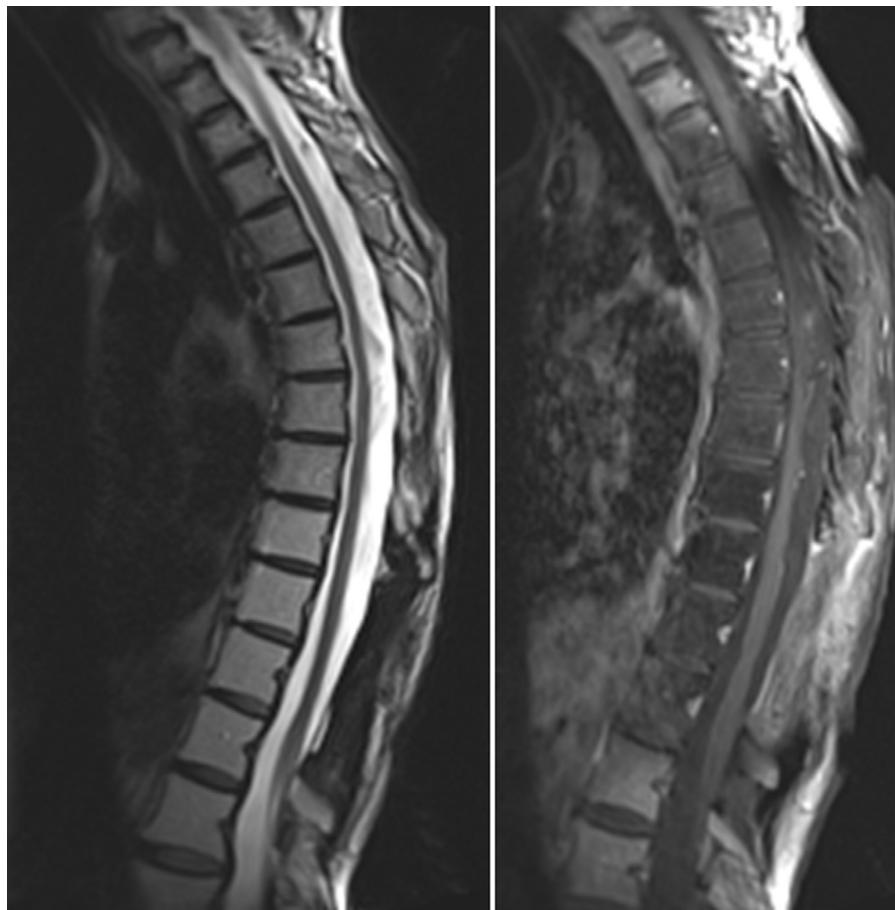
Postoperative sagittal T2 (Left) and T1 post-gadolinium (Right) magnetic resonance imagings (MRIs) obtained 6 months after surgery, demonstrating no evidence of residual or recurrent intramedullary tumor or leptomeningeal disease.
